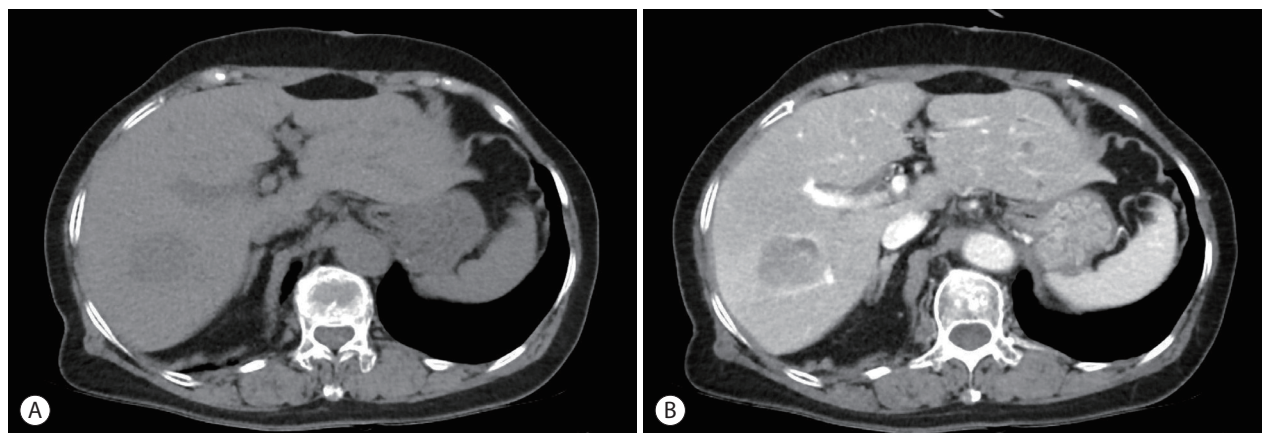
Initial computed tomography scan findings. A 3.6 cm sized lobulated mass is observed in segment VII, showing hypodensity compared to normal liver tissue in the pre-contrast phase (A) and peripheral rim enhancement in contrast images (B).
